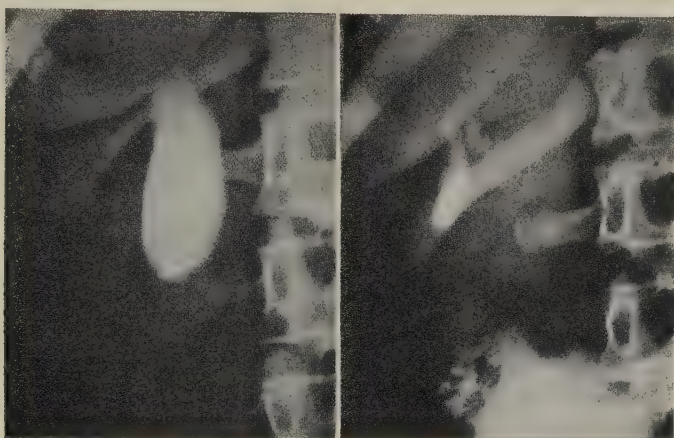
13. X-ray photographs of the Gall-Bladder of a Man before and after a meal of fat.
